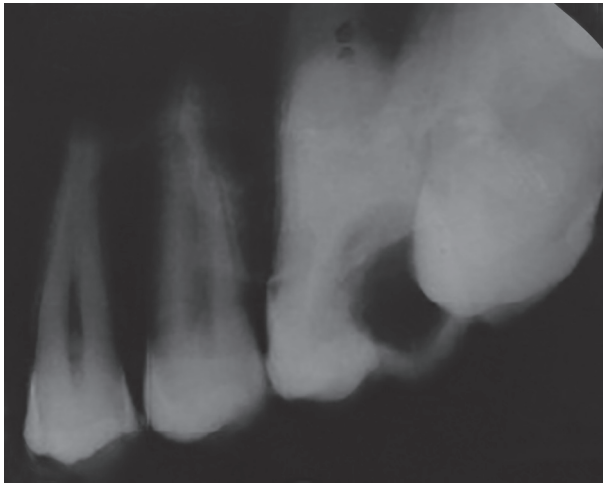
Preoperative radiograph showing highly calcified canals with 26
